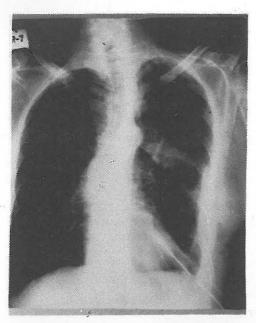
Roentgenogram on the first postoperative day
